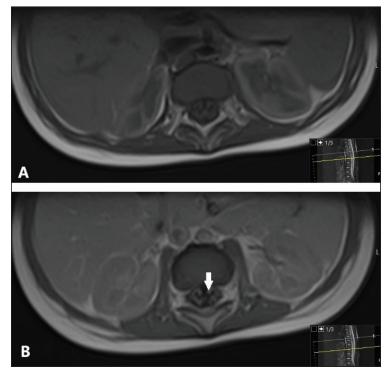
Sagittal FSE T1-weighted MR image in native series (A) and after Gadolinium contrast injection (B) demonstrates post-contrast enhancement (white arrow) of the anterior spinal nerve roots.
